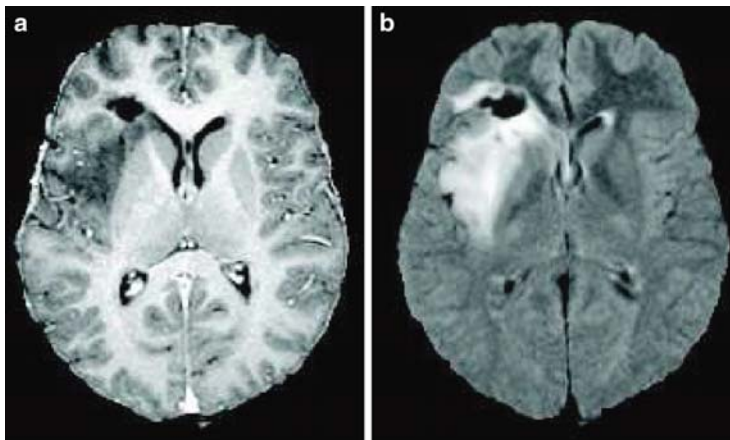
T1-weighted (a) and T2-weighted (b) images of a brain with tumor and edema. While the pathological area, defined as the tumor and the edema, appears as one single region, very contrasted from the other tissues in the T2-weighted image (*in white*), the same area decomposes in the T1-weighted image into the tumor (*dark grey*) and the surrounding edema (*lighter grey*, hardly distinguishable from grey matter)
